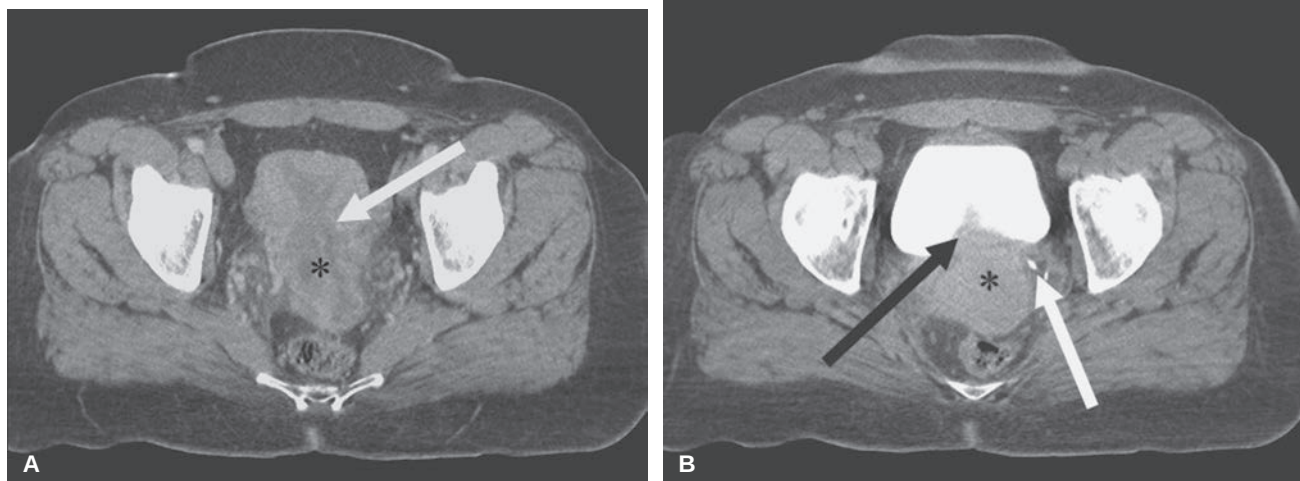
Stage IVA cervical carcinoma. Contrast-enhanced CT images at two levels (A, B) demonstrate a heterogeneous mass arising in the cervix (black asterisk) with extension into the uterus (white arrow in A) and bladder (black arrow in B). Note the loss of the normal periureteral fat plane around the left ureter (white arrow in B).
